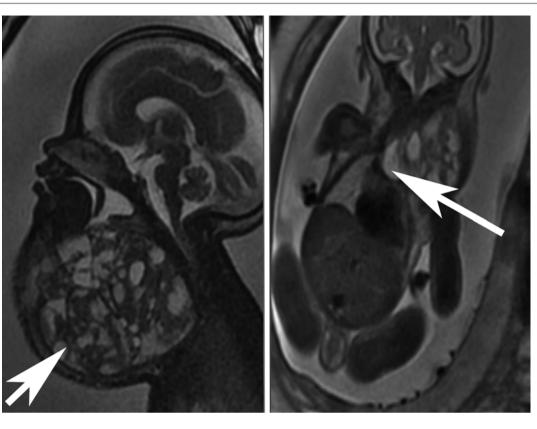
The *panel* on the *left* shows a sagittal section of a fetal MRI showing a very large cervical teratoma, the *arrow* is pointing at the mass, with both cystic and solid components. Calcifications are difficult to see on MRI but were present on ultrasound. The coronal section seen in the *panel* on the *right* shows a MRI image of the same patient demonstrating extension of the teratoma into the mediastinum through the thoracic inlet, the *arrow* is pointing at the mass. This mass resulted in a
